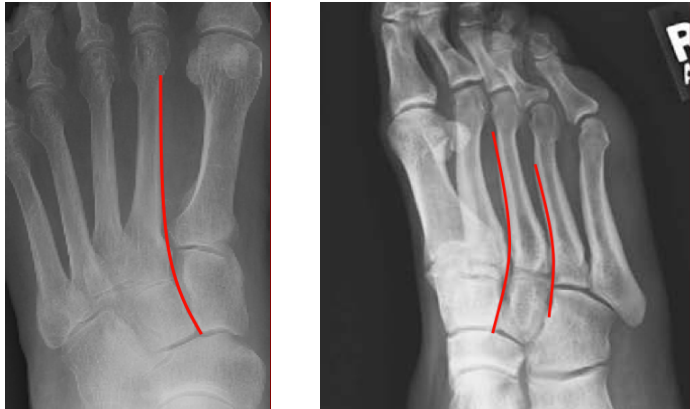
1B: (A) normal alignment of 2nd metatarsal on ap x-ray. (B) normal alignment of 3rd/4th metatarsal on oblique x-ray
